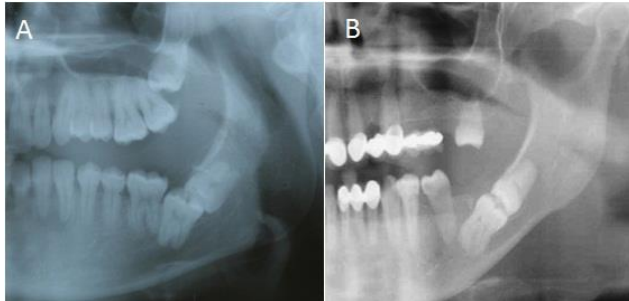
A. Panoramic radiograph showing impacted left second and third mandible molars with occlusal surfaces contacting each other in a single follicular space. B. Panoramic radiograph showing impacted left second and third mandible molars with occlusal surfaces contacting each other in a single follicular space.
